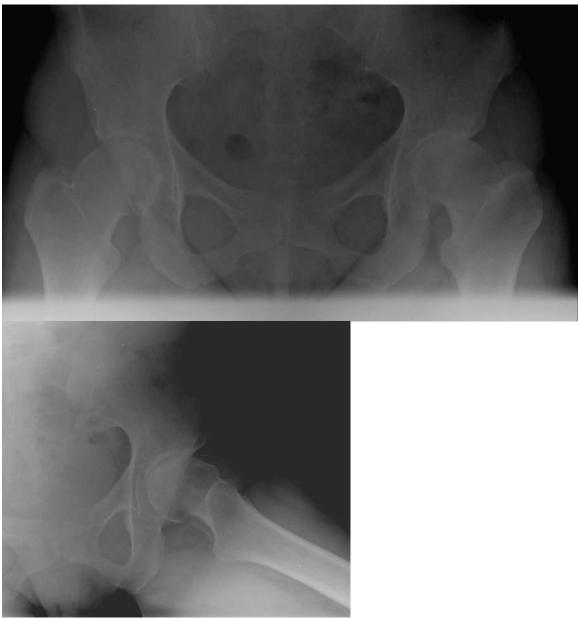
X-ray pelvis and affected left hip pre-treatment with PRP matrix graft
